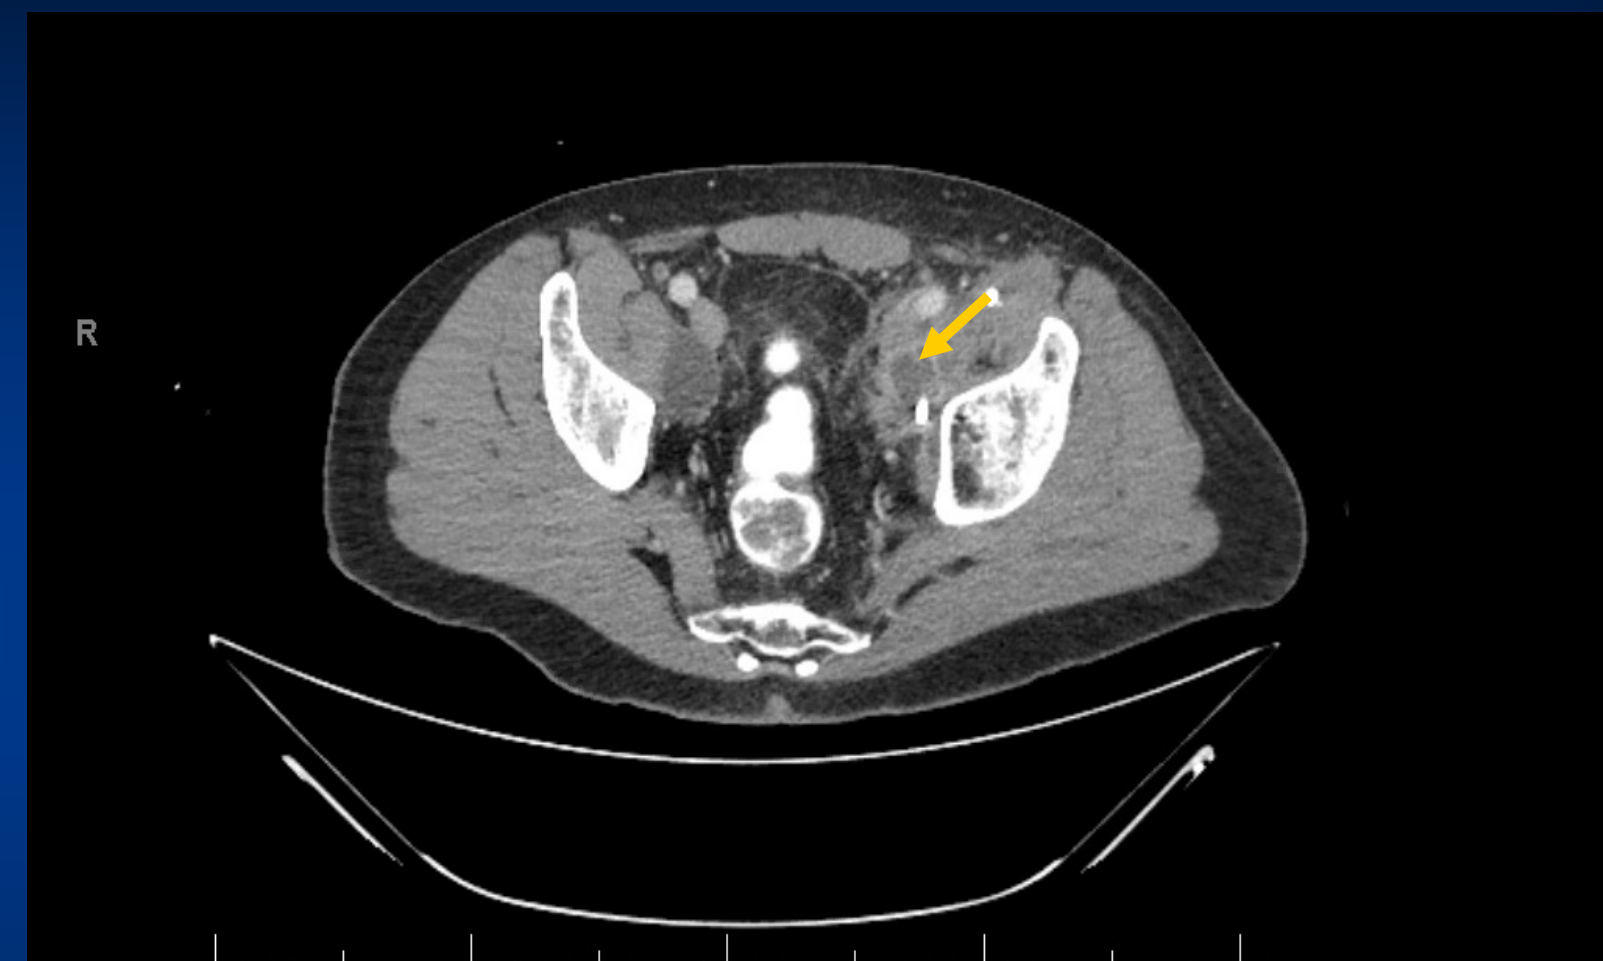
CT Abdomen/Pelvis showing collection within left iliopsoas muscle with enhancing wall and drain in place most consistent with an abscess. There is no evidence of connection to the bowel consistent with a fistula.
